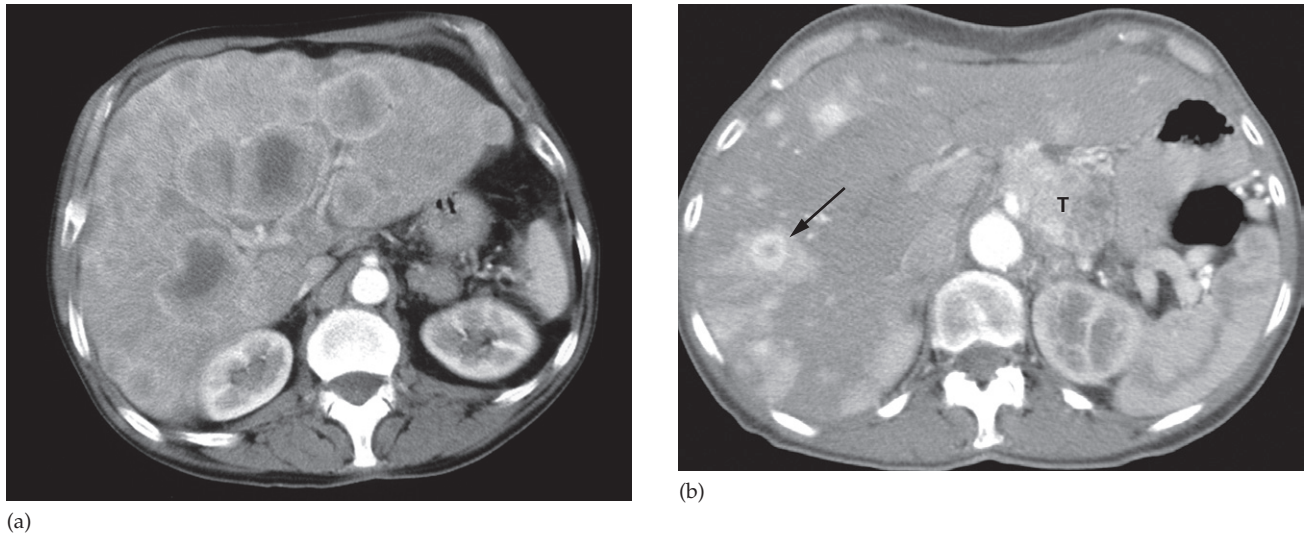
CT scan of liver metastases. (a) There are a large number of low density lesions in both lobes of the liver, which show enhancement around their edges. The patient had carcinoma of the bronchus. (b) Vascular metastases (arrow) due to a carcinoid tumour (T) appearing as areas of high density on this arterial phase image.
